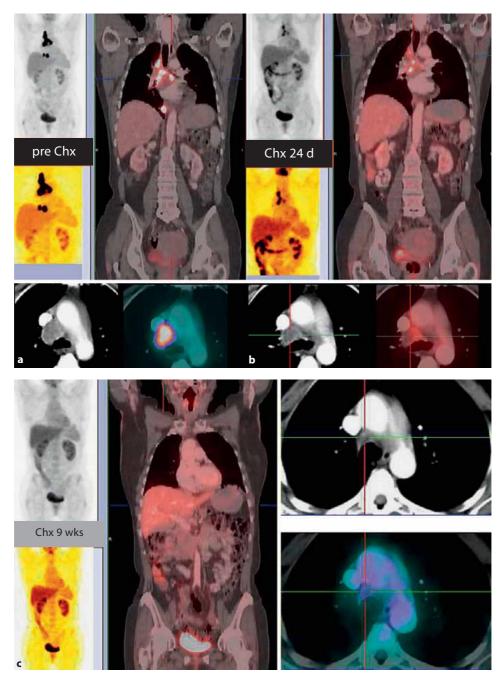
a–c Response assessment postchemotherapy by FGD-PET/CT: changes in tumor metabolism (PET) precede size changes (CT). Therapy response after one cycle (24 days) chemotherapy demonstrated by FDG-PET (a), when CT image still shows enlarged lymph node (b), and at 9 weeks (c): metabolic complete remission (mCR).
